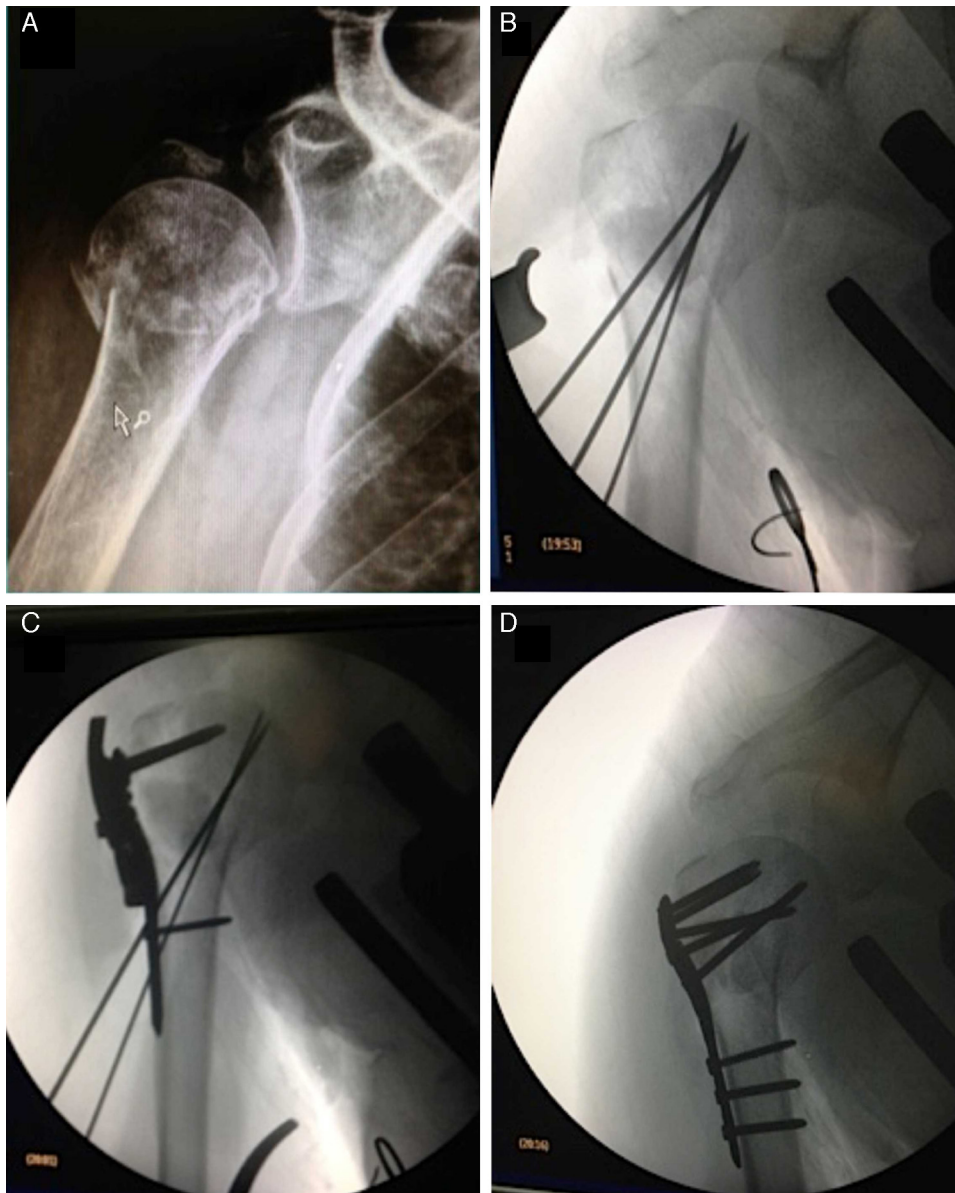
(A) Anteroposterior radiograph of the right shoulder showing valgus impacted fracture of the proximal humerus. (B) Intraoperative fluoroscopy showing fracture reduction, synthetic graft and provisional fixation with metal wires. (C) Fixation using locked plate. (D) Final osteosynthesis.
